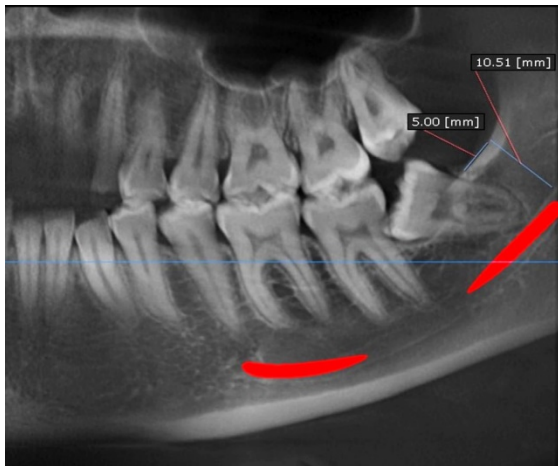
CBCT panoramic view showing the distance of the point of drilling away from inferior alveolar canal.
